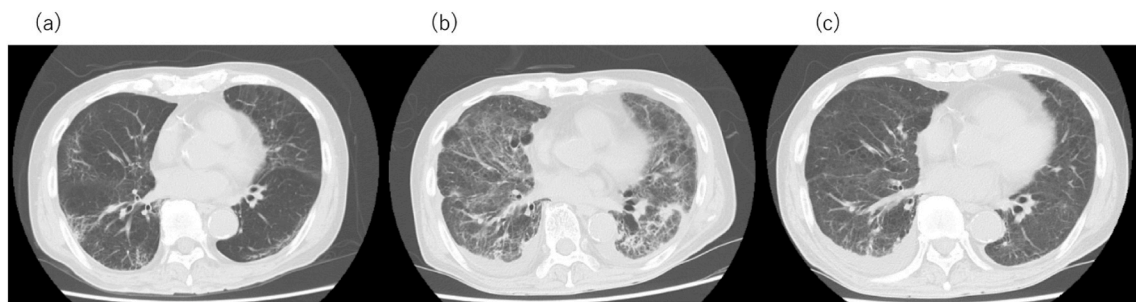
Serial chest computed tomography (CT) findings (a) day 15, (b) day 49, and (c) day 86.
